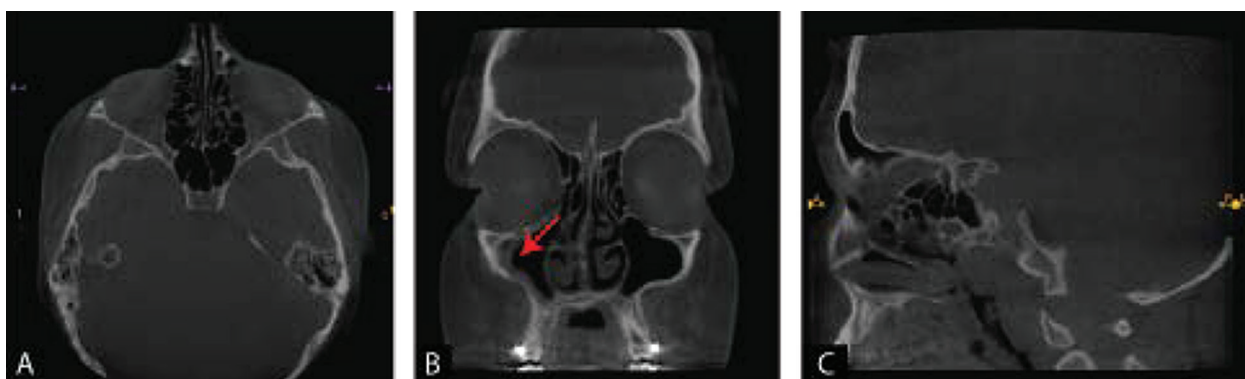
Postoperative CBCT of the paranasal sinuses, evaluated in axial (A), coronal (B), and sagittal (C) planes, demonstrates relatively normal postoperative anatomy (A, C). Note a focal soft tissue thickening within the right maxillary sinus, as indicated by the arrow (B). (The image is from author's archive.)
